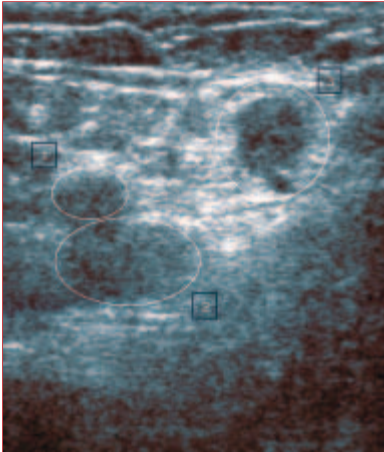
Compression duplex sonography at the groin one day after the intervention
